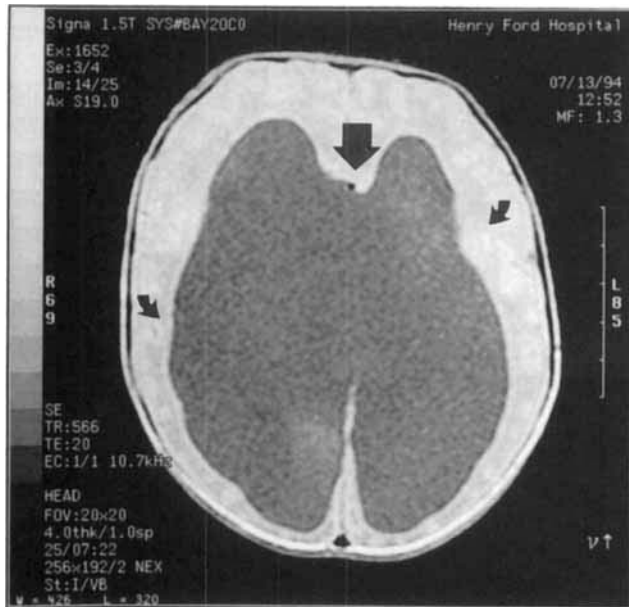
Patient 1, MRI of the brain. The position of the anterior cerebral artery (large arrow) relative to the cerebral cortex indicates absence of the corpus callosum in spite of the marked dilatation of the lateral ventricles (small arrows). Dilatation of the lateral and third ventricles was due to aqueductal obstruction.
